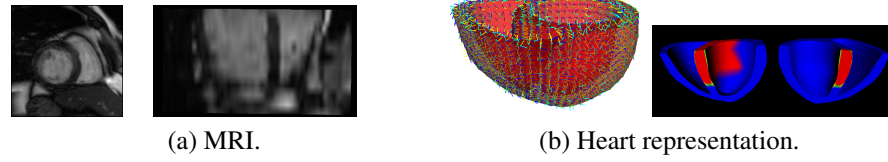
Real data. (a) MRI. (b) Left: tissue structures (f, s, n : fiber, sheet, sheet normal: blue, yellow, cyan). Right: infarcted region shown in red.
